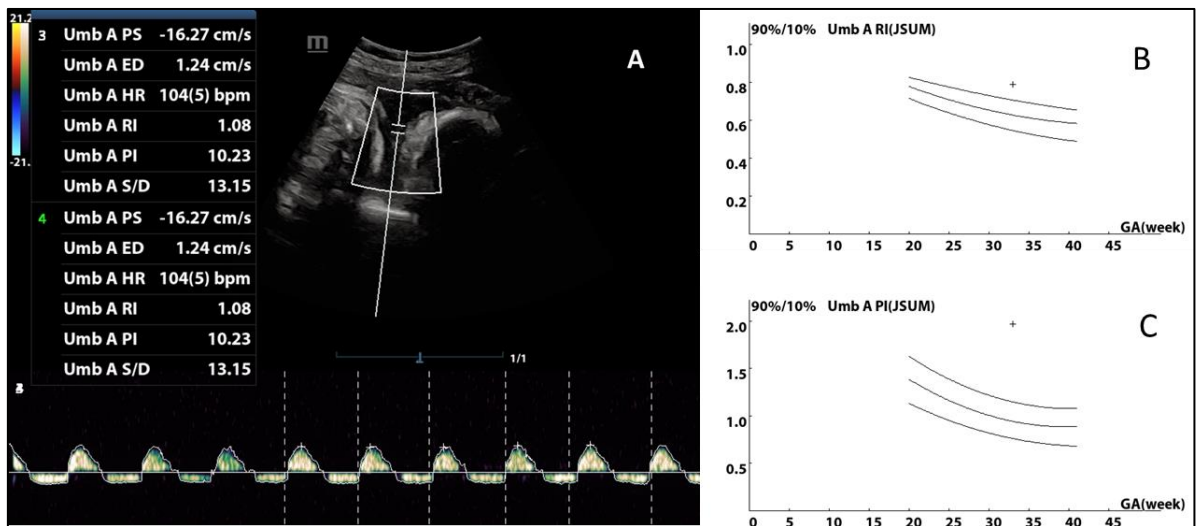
Umbilical artery color and spectral Doppler [A], showing diastolic reversal, [B]. very high resistance index [RI-0.108] above 90<sup>th</sup> percentile and beyond the limit of 0.1 and C). very high pulsatility index [PI-10.23] above 90<sup>th</sup> percentile per age and beyond the limit of 2.0 [almost five times high than the cut off limit]
